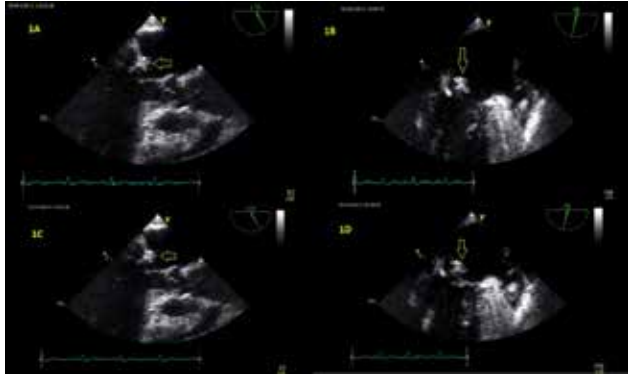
(A-D) Vegetation at echocardiography.
